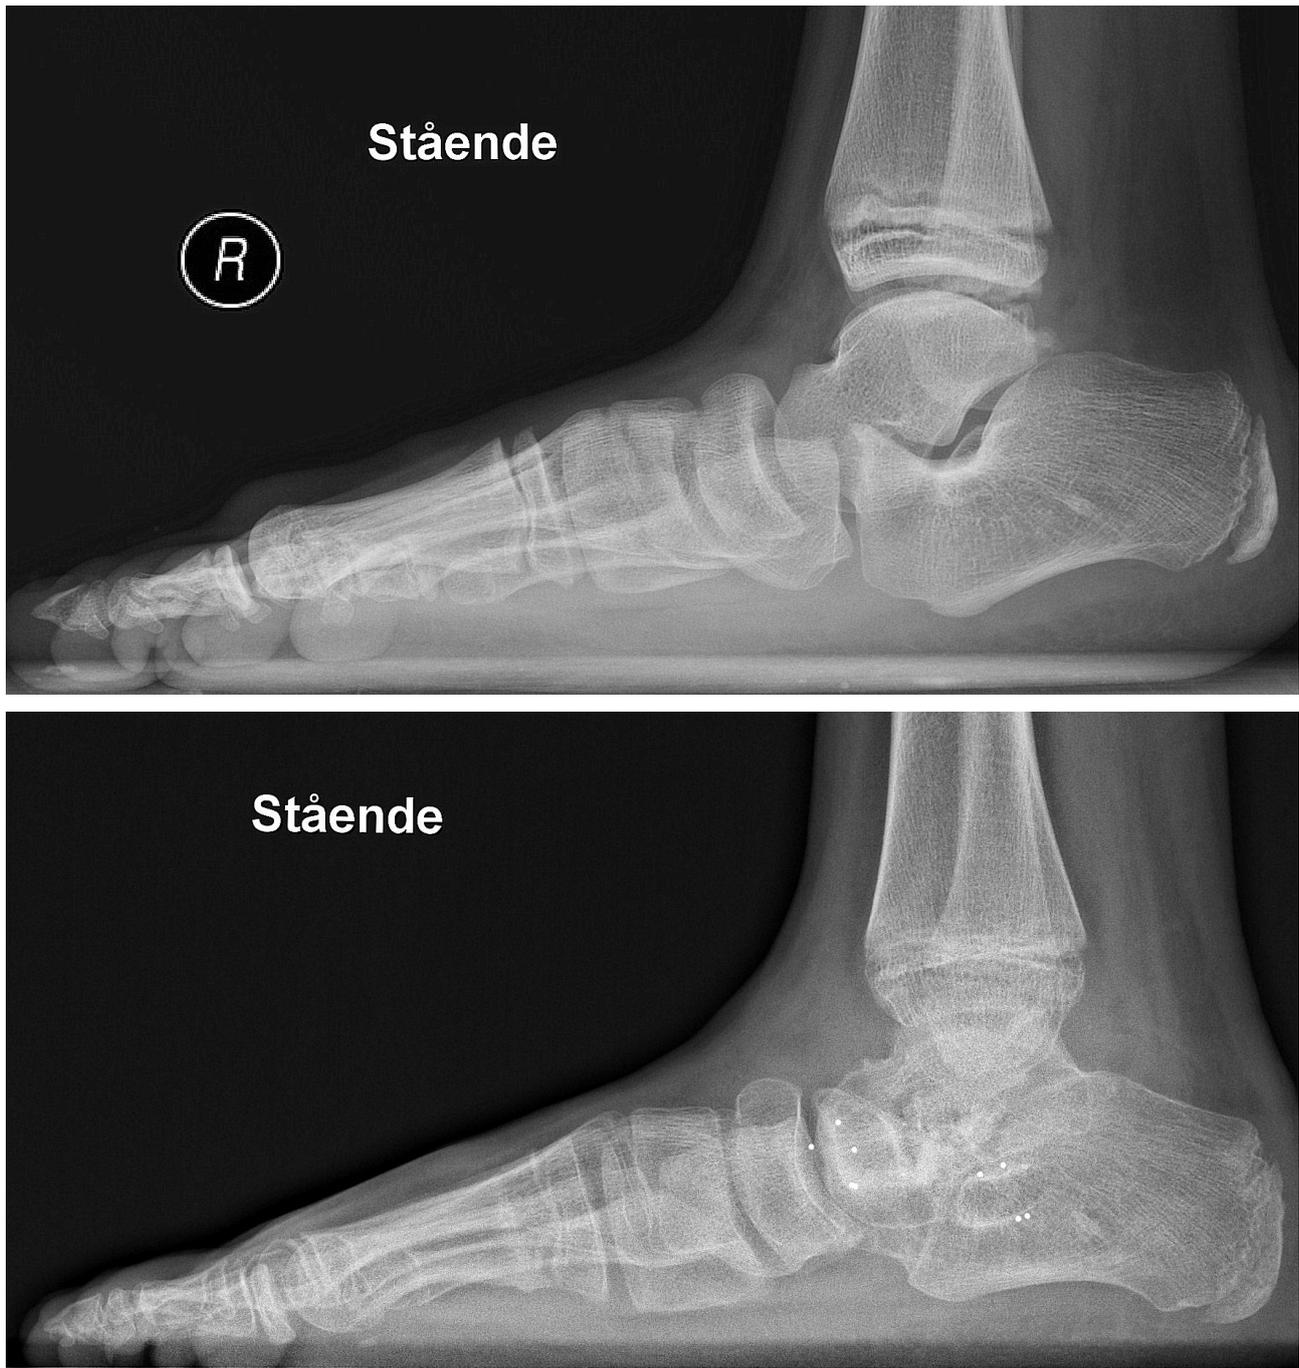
Pre- and postoperative standing radiographs of a calcaneal lengthening osteotomy in an 11-year boy. The figure text ‘Stående’ is Danish for standing.
